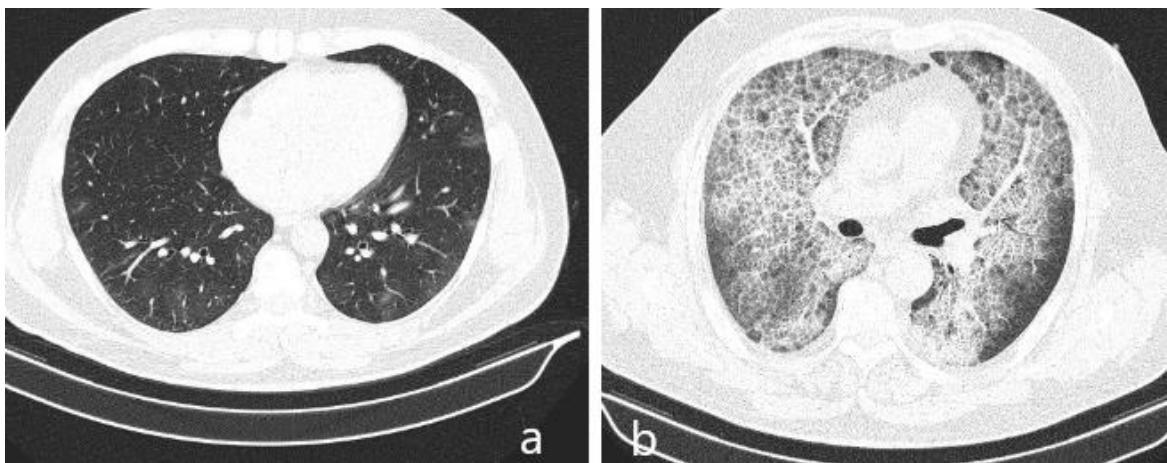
a – 57-year-old patient with GGO, HRCT was performed on 5th day after positive RT-PCR. b – 62-year-old patient with crazy-paving on 9th day of positive RT-PCR test. The HRCT show diffuse bilateral crazy-paving opacification.
